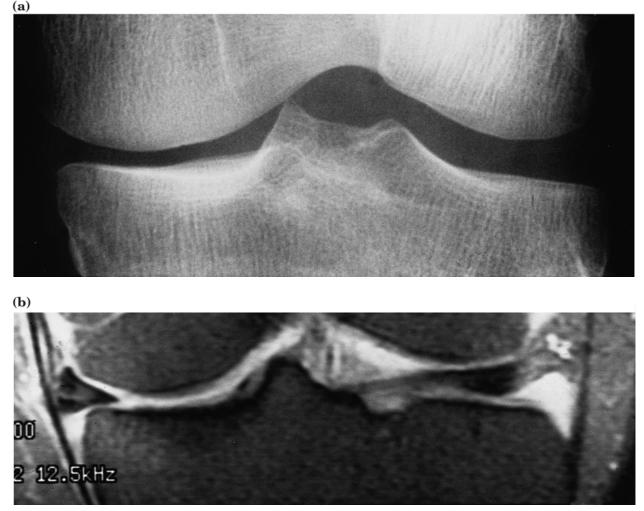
(a) An AP view of the knee demonstrates grade I narrowing medially using the qualitative scale. (b) The corresponding proton density weighted fat saturation MR image demonstrates 4 mm of subluxation of the medial meniscus beyond a vertical line through the medial border of tibia. The articular cartilage is relatively well preserved.
